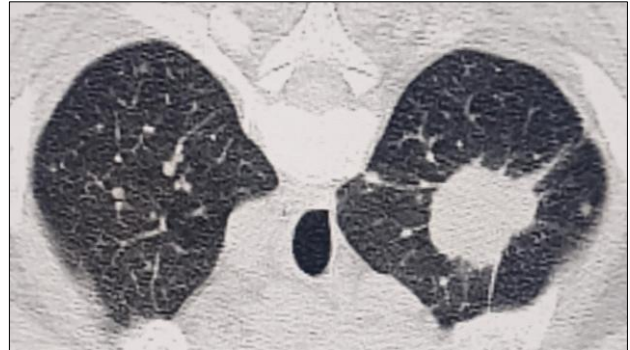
HRCT thorax showing right upper lobe mass with multiple pulmonary metastases and pericardial effusion.
